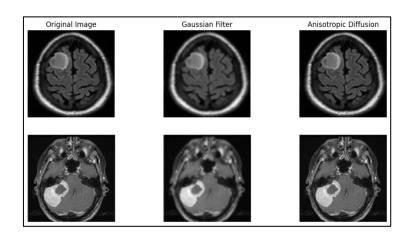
Preprocessed MRI Brain Images by Gaussian and Anisotropic Diffusion
